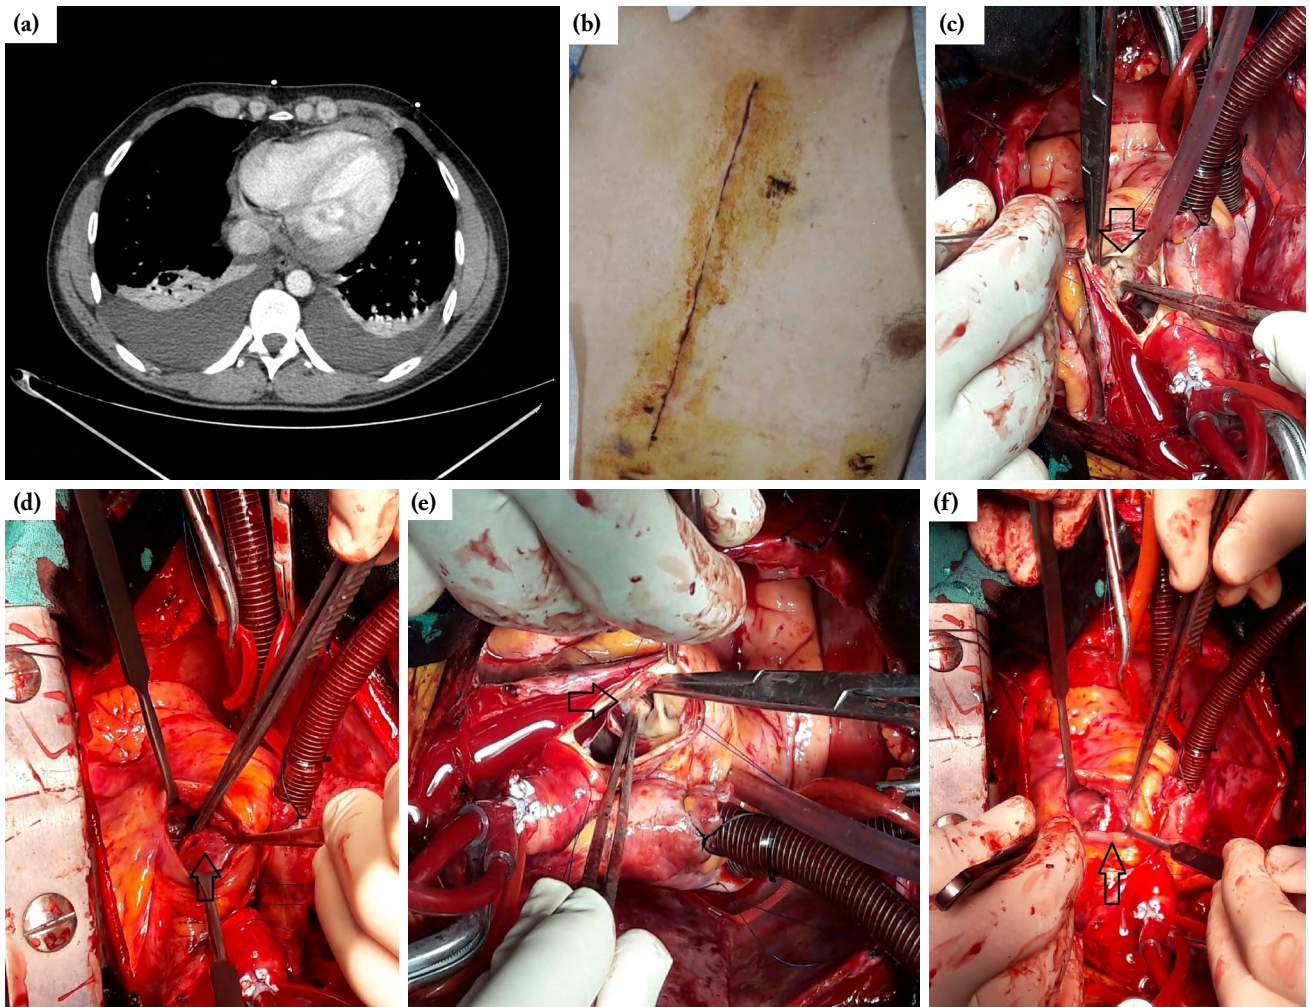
(a) Computed tomography scan showing pericardial and bilateral pleural effusion. (b) The stab wound injury in the second left parasternal intercostal space. (c) Aortic slit-like linear injury (arrow). (d) Right ventricular slit-like linear injury (arrow). (e) Aortic side of repair with two Teflon pledgeted sutures (arrow). (f) Right ventricular side of repair with over and over suture supported with Teflon felts on both sides (arrow).
